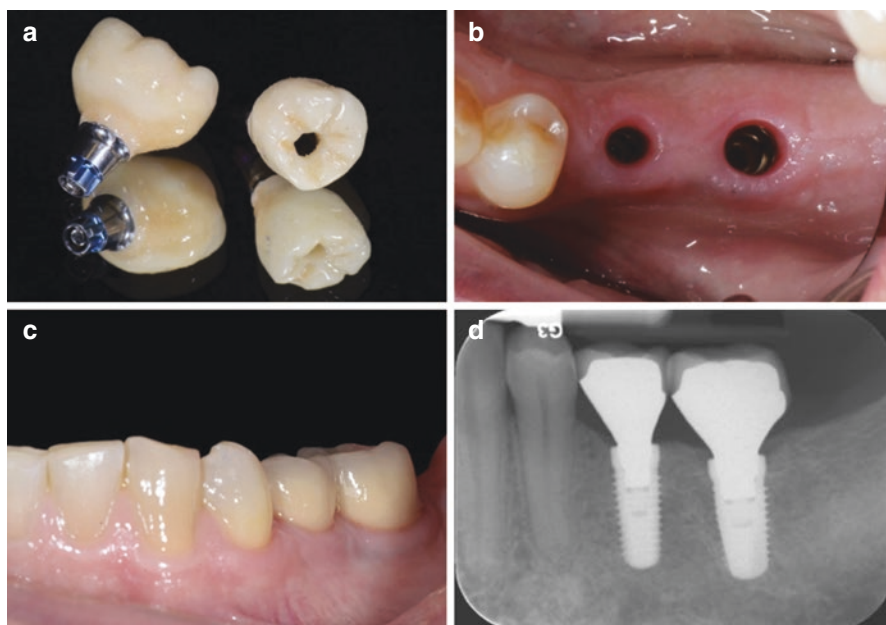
Screw-retained implant crowns are retrievable and having no cement line or potential for excess cement often demonstrate outstanding soft tissue health. (a) Single-piece screw-retained abutment/metal ceramic crowns. (b) Implant sites demonstrate excellent peri-implant gingival health. (c) Final placement of screw-retained implant restorations. (d) Periapical radiograph of metal ceramic screw-retained crowns restoring tapered bone level implants at sites #19 and #20 (Photos courtesy of Dr. Florian Kernan)
